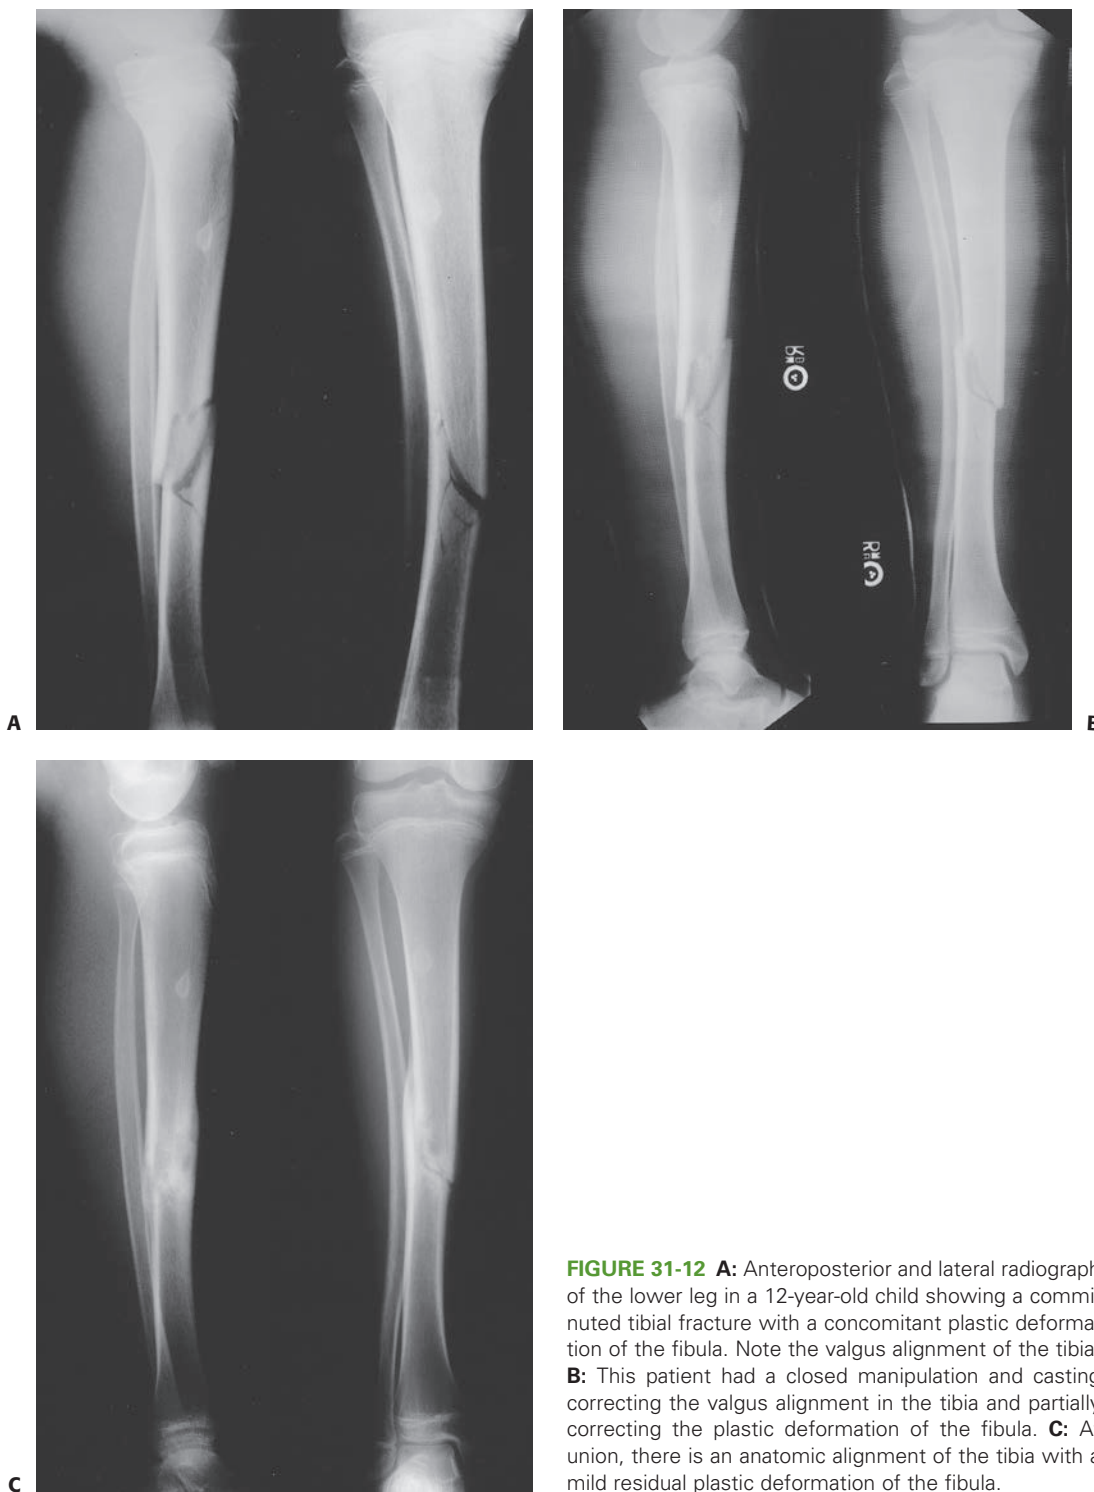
A: Anteroposterior and lateral radiograph of the lower leg in a 12-year-old child showing a comminuted tibial fracture with a concomitant plastic deformation of the fibula. Note the valgus alignment of the tibia. B: This patient had a closed manipulation and casting correcting the valgus alignment in the tibia and partially correcting the plastic deformation of the fibula. C: At union, there is an anatomic alignment of the tibia with a mild residual plastic deformation of the fibula.
